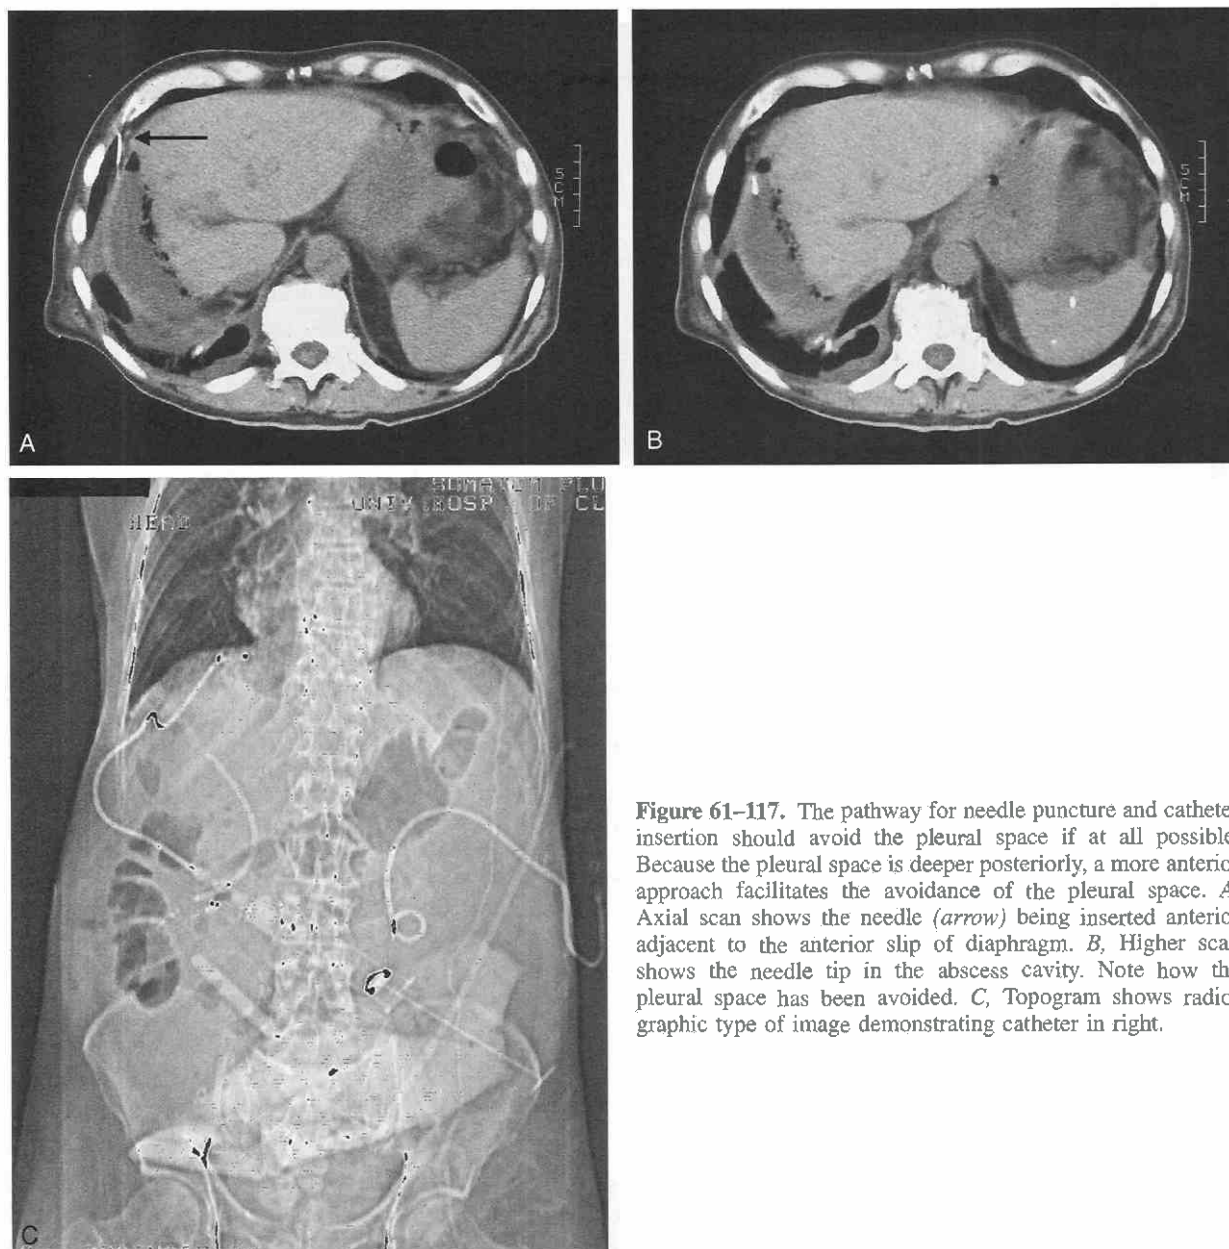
The pathway for needle puncture and catheter insertion should avoid the pleural space if at all possible. Because the pleural space is deeper posteriorly, a more anterior approach facilitates the avoidance of the pleural space. *A*, Axial scan shows the needle (*arrow*) being inserted anterior adjacent to the anterior slip of diaphragm. *B*, Higher scan shows the needle tip in the abscess cavity. Note how the pleural space has been avoided. *C*, Topogram shows radiographic type of image demonstrating catheter in right.
